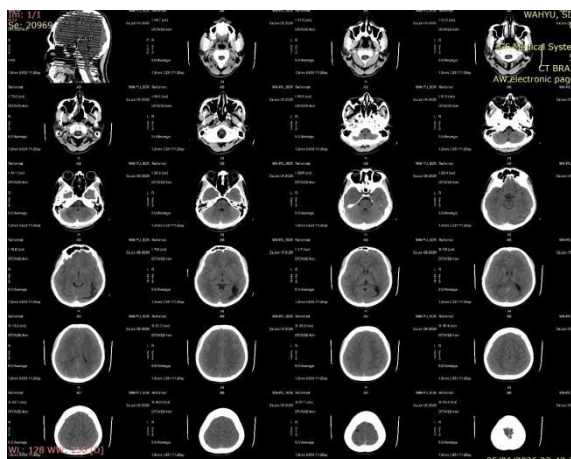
Follow-up Brain CT Scan
